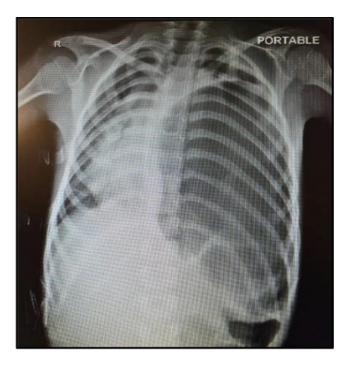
Preoperative chest radiograph showing large hyperlucency, and the dimension were approximately 18×10 cm in the left hemithorax. A significant mediastinal shift to the right can be observed.
